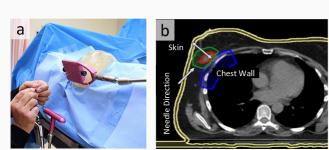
a) PBSI implant showing needle insertion through template. b) Axial CT slice showing the CTV, PTV, and direction of needle insertion.
